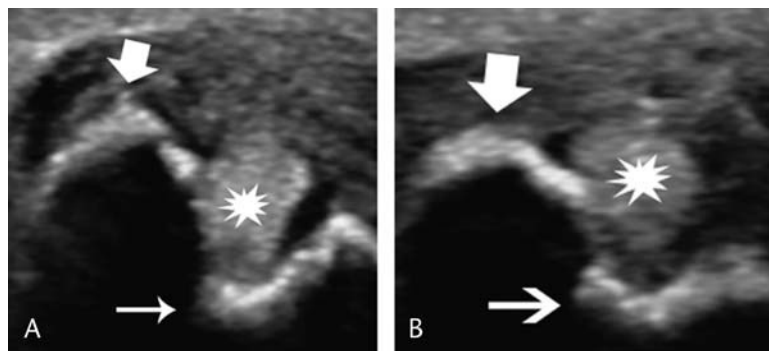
Postoperative neutral (A) and supinated (B) short axis ultrasound images of the wrist show stability of the ECU tendon (star) without subluxation from the groove (arrow). Note that the ulnar groove has been deepened. Thick arrow indicates ulnar styloid.
